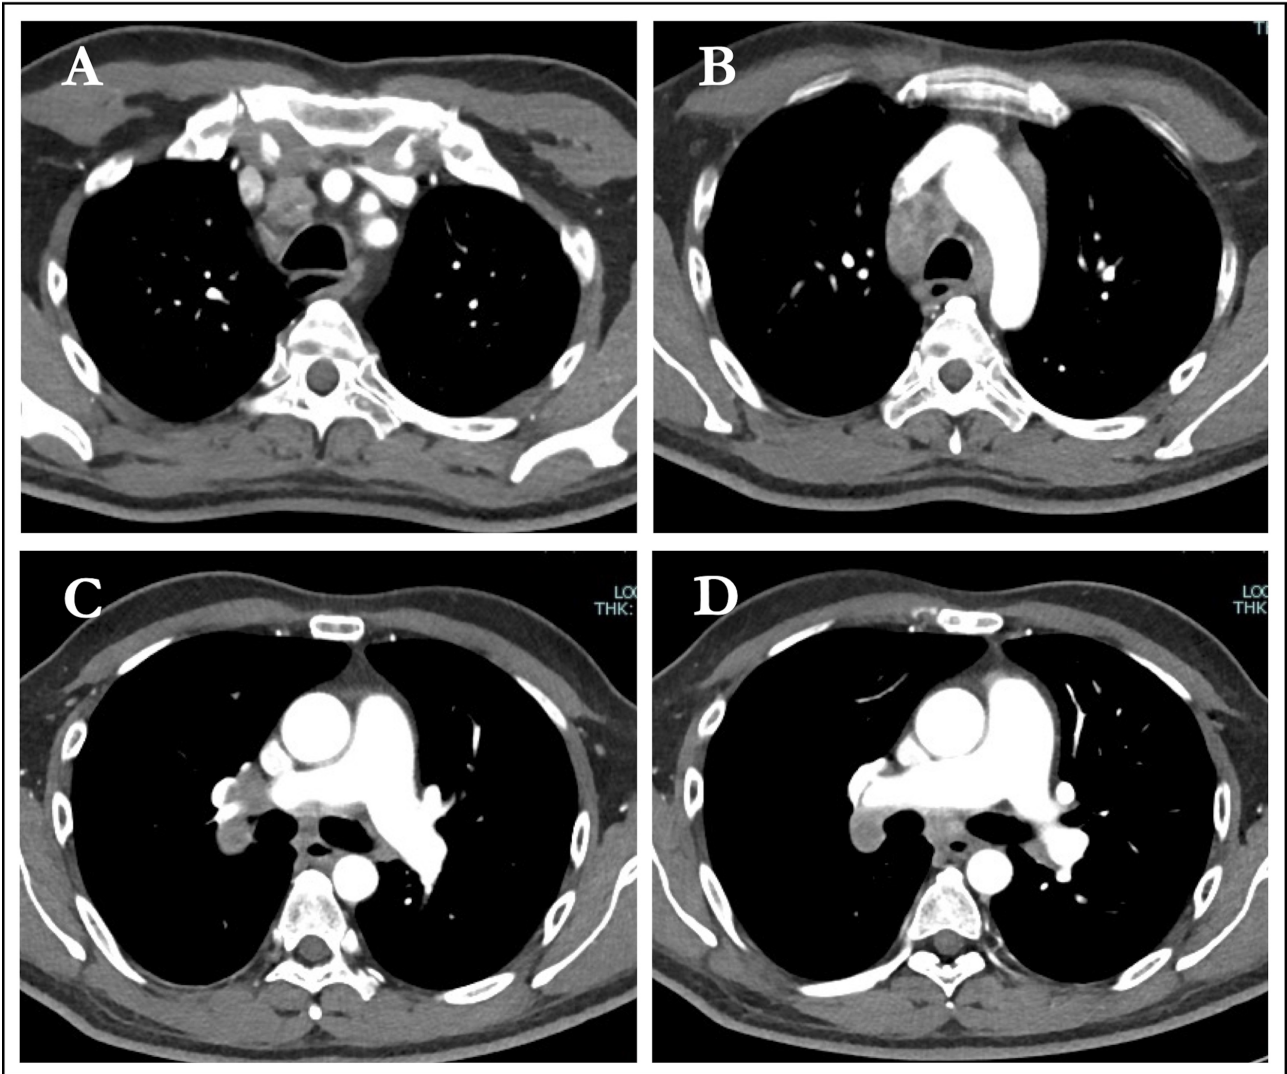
Chest CT scan showing right paratracheal (A, B), paraaortic (B), right hilar (C, D) and subcarinal (D) lymph adenopathies.
